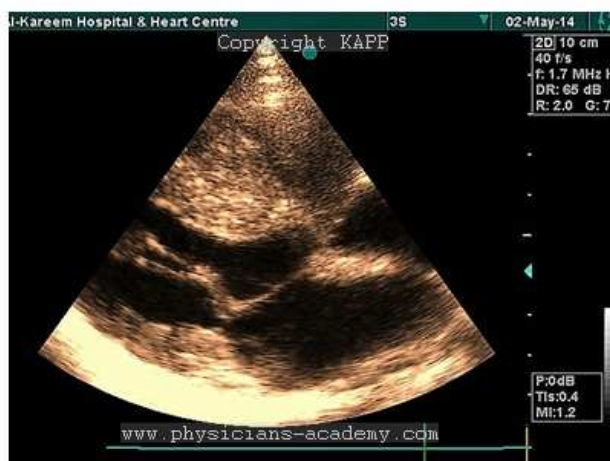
2D-Echo. Parasternal Long axis View.
